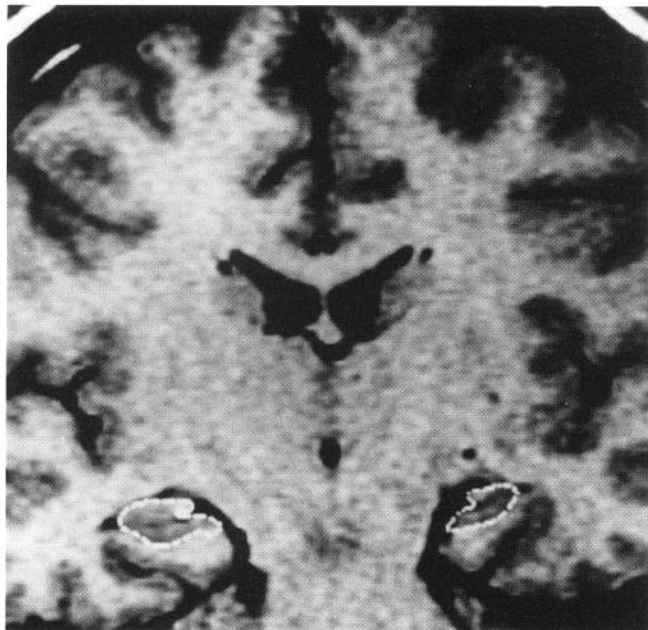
Coronal MRI scan passing through the bodies of the hippocampi (outlined bilaterally) showing severe left hippocampal atrophy (ratio = 0.59). Severe hippocampal sclerosis was found on pathological examination.
